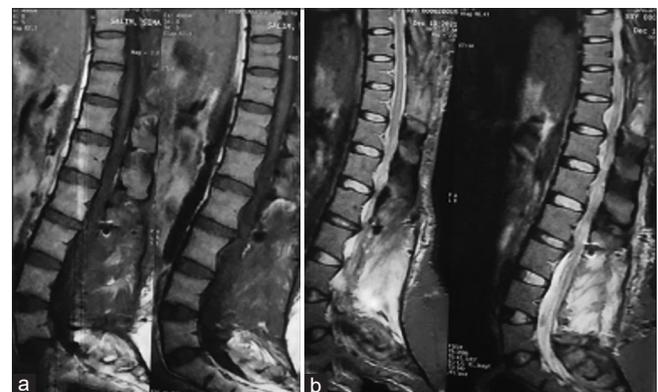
Postoperative thoracolumbar MRI, (a and b) T1 and T2 sagittal weighted images show appropriate decompression of lumbar and low thoracic spine.
